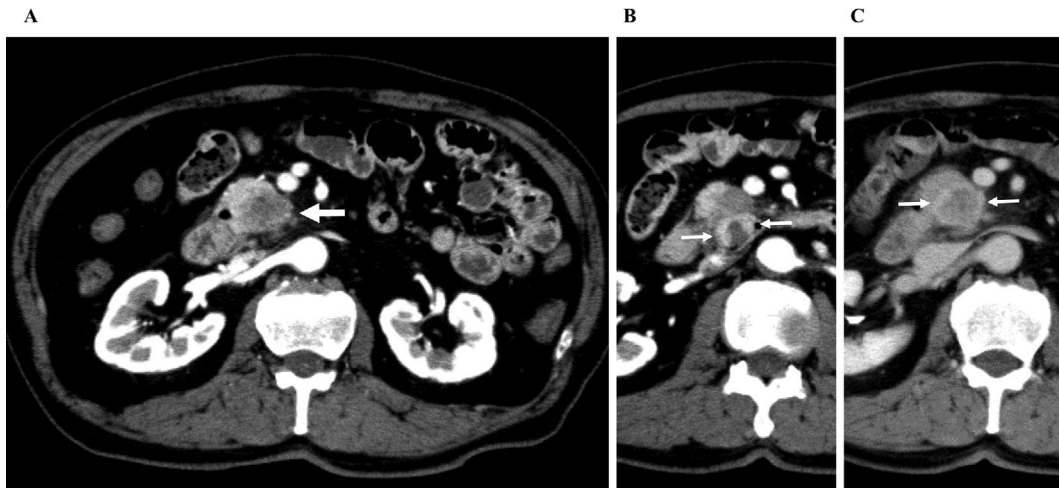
Enhanced computed tomography (CT). The arterial phase (47 seconds after contrast injection) of the CT image showed a low-attenuated mass located at the pancreatic uncinate process (arrow) (A) continuously invading the duodenum with marginal enhancement (small arrow) (B). The tumor was slightly enhanced at the late phase (3 minutes), especially at the margin (small arrows) (C).
